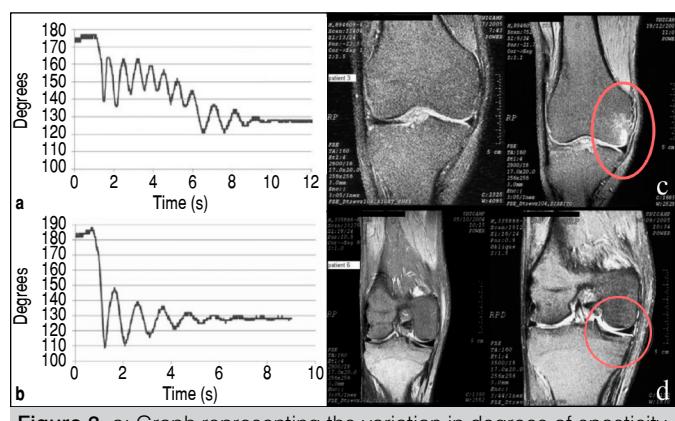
a: Graph representing the variation in degrees of spasticity in the pendular test before the NMES; b: Similar graph in 'a', but after NMES; c: MRI scan with contusion of the medial bone (red circle); d: MRI points to medial meniscus injury with internal decrease.^{17,18}
